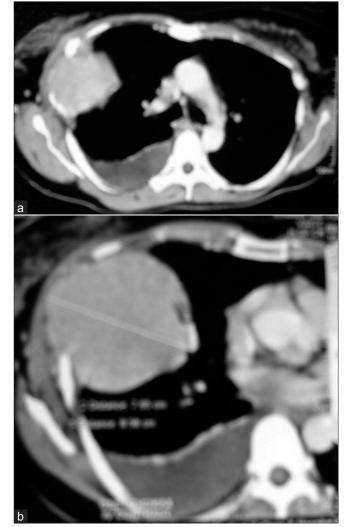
(a-b) Contrast -enhanced computed tomography of the chest revealed a well-defined hypodense soft tissue mass on right side abutting the chest wall with invasion of fifth rib and associated pleural effusion
